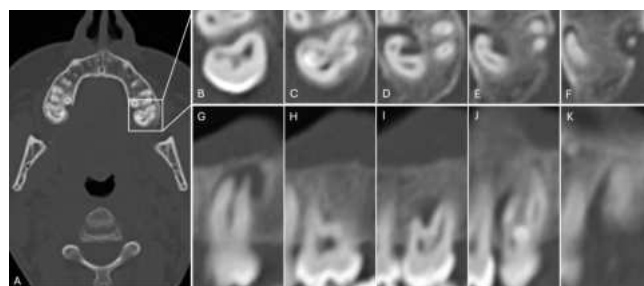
CT with details of tooth 27, (C) and (J) showing a *dens invaginatus* type III.
